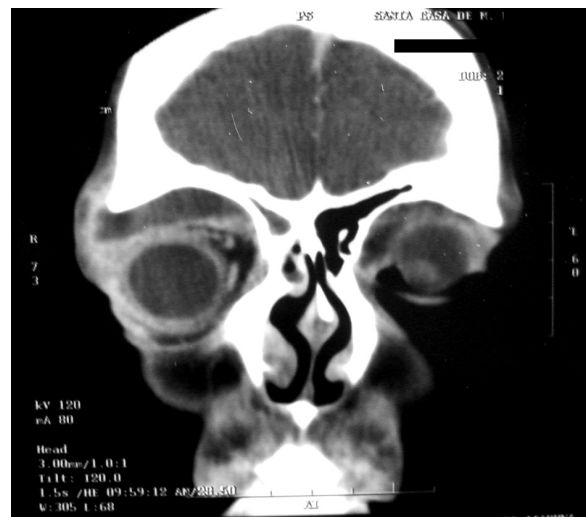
CT scan showing right ethmoidal sinusitis and a superior subperiosteal abscess, displacing the globe inferiorly.
